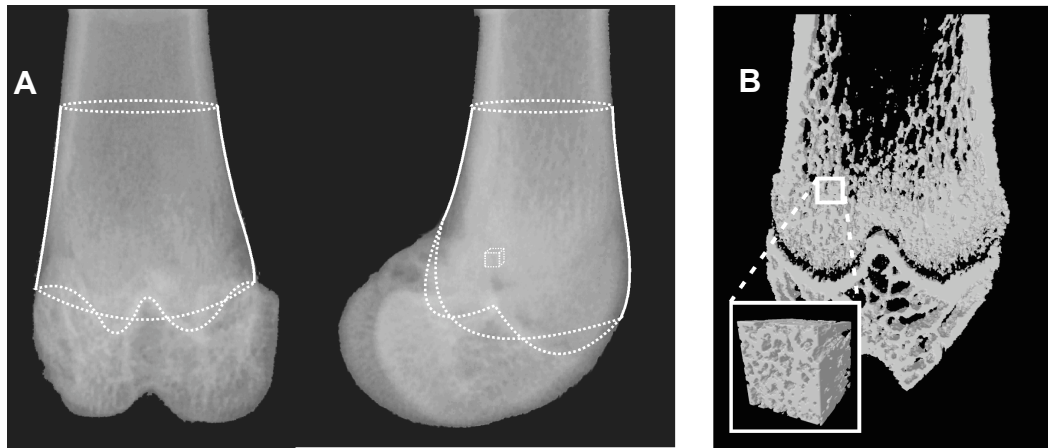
The micro CT analysis of the distal metaphysis of femur. (A) The volume of interest (VOI) consisted a 4.5mm longitudinal section extending proximally from the mid-growth plate. (B) 3D analysis of the trabecular bone region.
